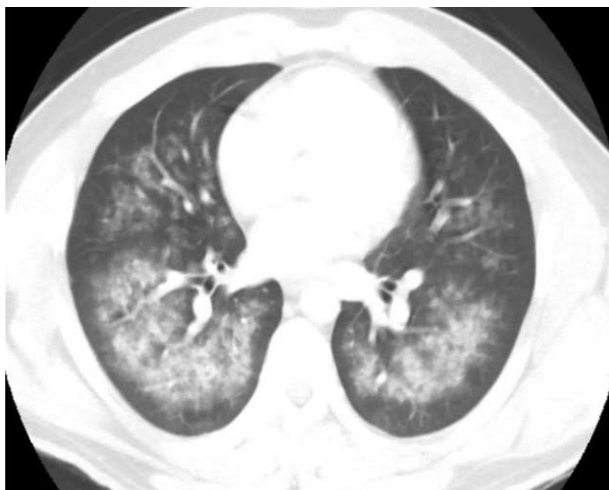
Chest CT scan, axial view upon admission.
